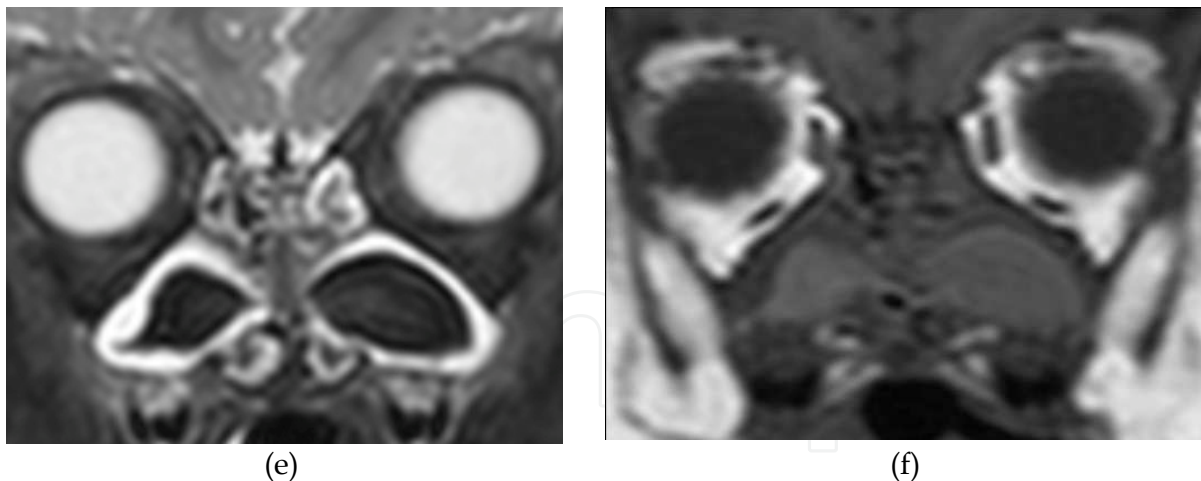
Two-year-old boy with cystic fibrosis (CF). (a) Coronal CT with bone algorithm shows bilateral, homogeneous, ethmomaxillary soft tissue masses (asterisks). (b) Coronal CT with soft tissue algorithm can differentiate the mucosal lining (arrows) from the sticky mucous centrally. (c) Axial CT demonstrates the advanced medial bulging of the lateral nasal walls (arrows). (d) Coronal CT demonstrates sphenoid sinus hypoplasia seen in all CF patients. (e) Coronal MR with STIR sequence differentiates the mucosal lining from the pus-filled maxillary sinus lumen centrally. (f) The corresponding coronal MR T1 sequence is mandatory in order to discriminate the signal void lumen at STIR sequence from air-filled lumen.
